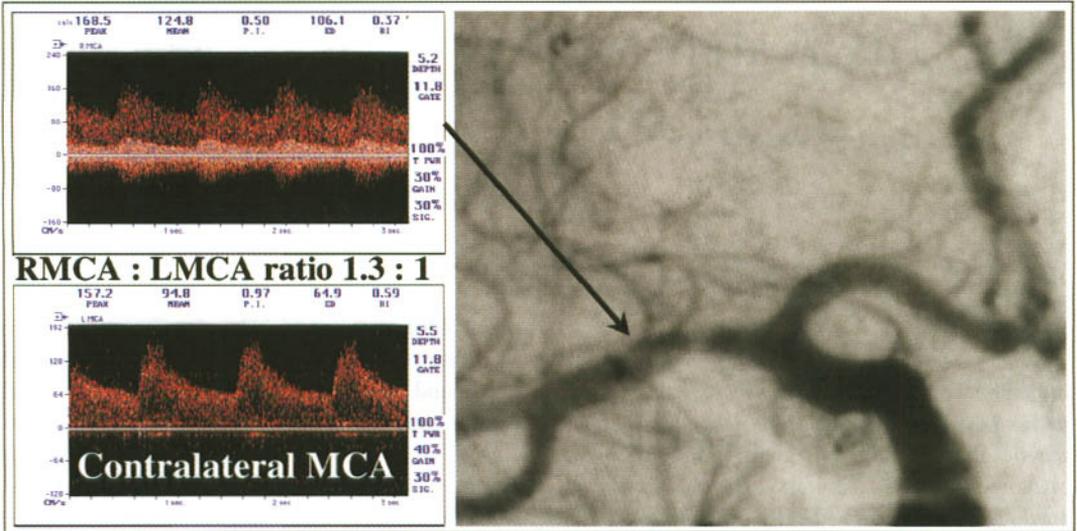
A false-positive transcranial Doppler diagnosis of middle cerebral artery stenosis of > 50% by the WASID criteria.
